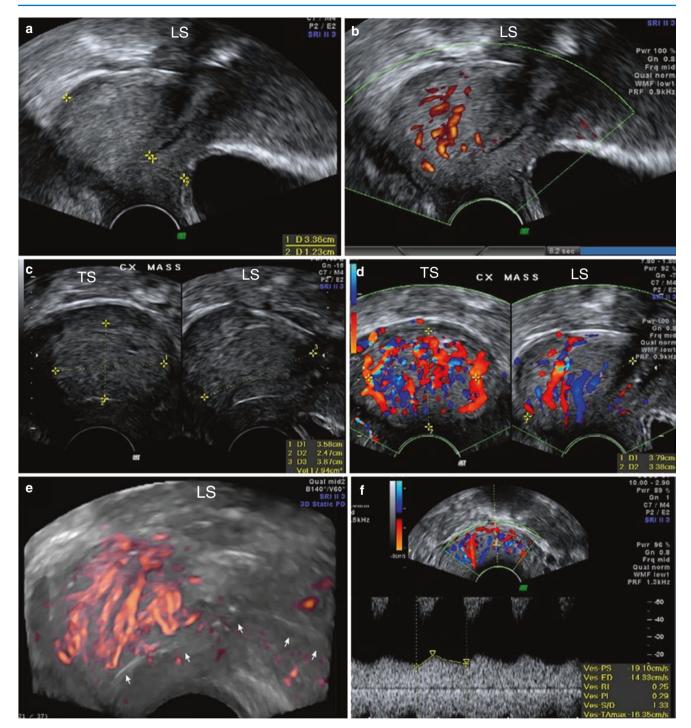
42-year-old lady with a history of white discharge since 2 years and post-coital bleeding since 5 months. (a) On greyscale, the posterior wall of the cervix appeared thick and bulky. (b) Increased flow is seen in this bulky posterior wall on Doppler. (c) Isoechoic mass measured on 2D greyscale. (d) High vascularity (colour score of 4), seen in the mass, raises a high suspicion of malignancy. (e) 3D glass rendered image with power Doppler shows the abnormal vascular pattern (irregular calibre, looping and abnormal branching) which is seen in malignant masses. With rotation and cine loop, this is even better perceived. The cervical canal is seen (*small arrows*), and the tumour is seen to be endophytic. (f) Flow in the tumour shows a low RI of 0.29. In some other vessels of the same mass, the RI was higher (up to 0.67). (g, h) Iliac vessels should be traced in all cases of carcinoma of the cervix to look for metastatic iliac lymph nodes. Here, none were seen. *HPE:* endocervical adenocarcinoma
